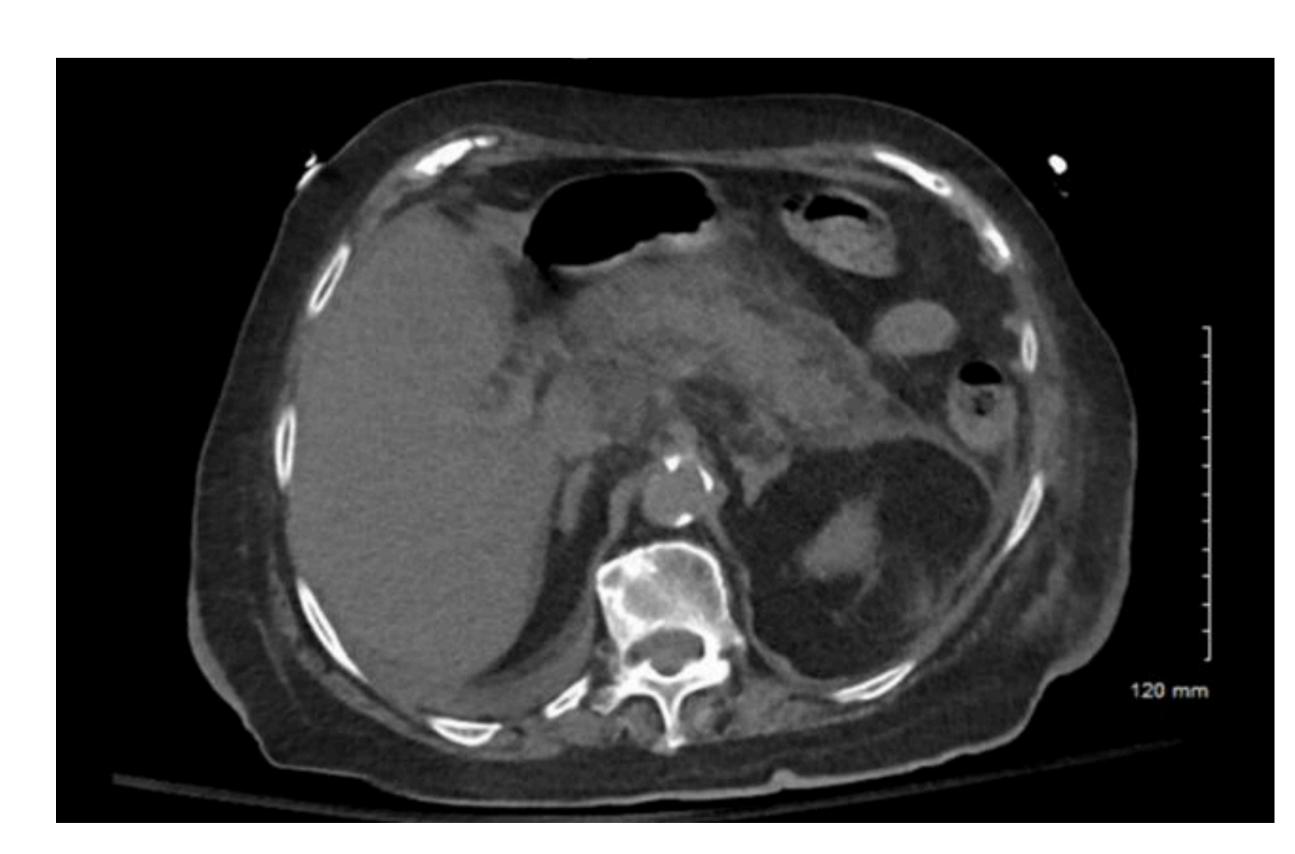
CT A/P. Severe peripancreatic and pancreatic edema.
